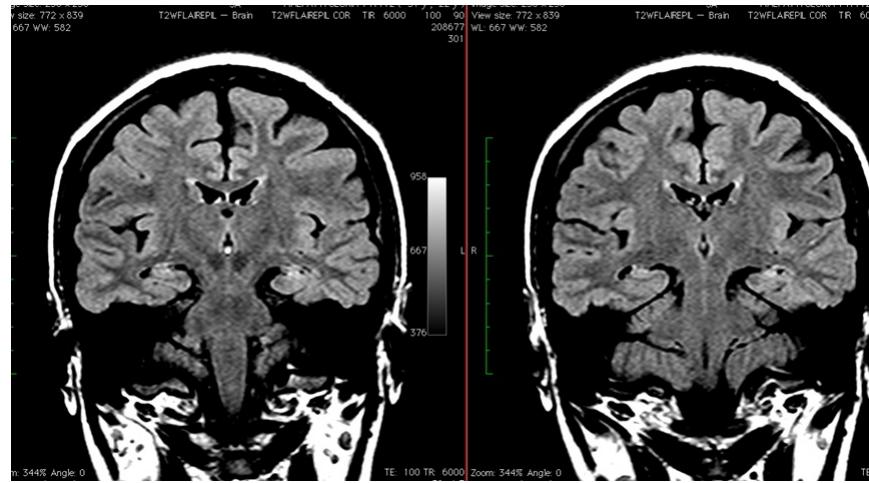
MRI (coronal section) of TLE patient with mesial temporal sclerosis (sx).
